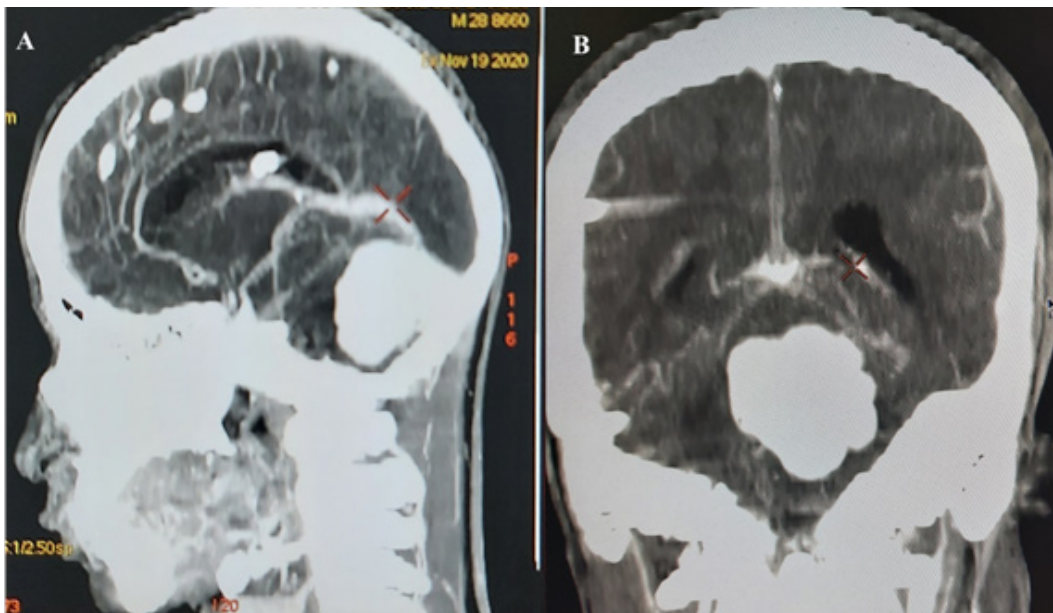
(A and B) : Brain CT angiography with sagittal (A) and coronal (B) reconstruction, showing aneurysmal dilation of the vein of Galen at the level of the pineal region with dilation of the right sinus and intraparenchymal calcifications.
